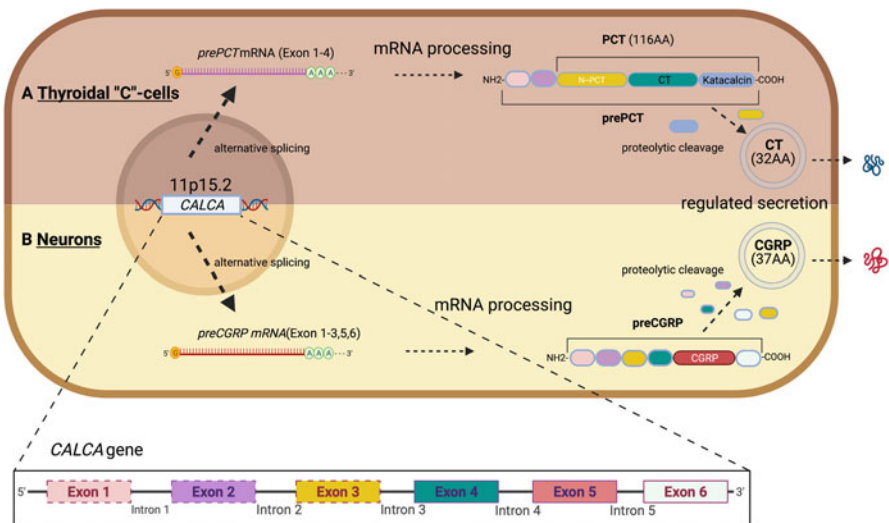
Structure of the *CALCA* gene. (a) *CALCA* gene expression in thyroidal C-cells in the healthy organism. Once transcribed, PCT-mRNA strands are synthesized through alternative splicing. The PCT-mRNA is then translated into the PCT protein. After proteolytic cleavage of the N- and C-terminus, mature CT is stored in vesicles until release upon specific stimuli (e.g., serum calcium levels or other hormones). (b) In neurons, alternative splicing results in the synthesis of CGRP mRNA. After translation, CGRP protein is stored in vesicles and transported to nerve endings for release. AA Amino acid, CT calcitonin, CGRP Calcitonin-gene-related peptide, *CALCA* Calcitonin-related polypeptidealpha gene
